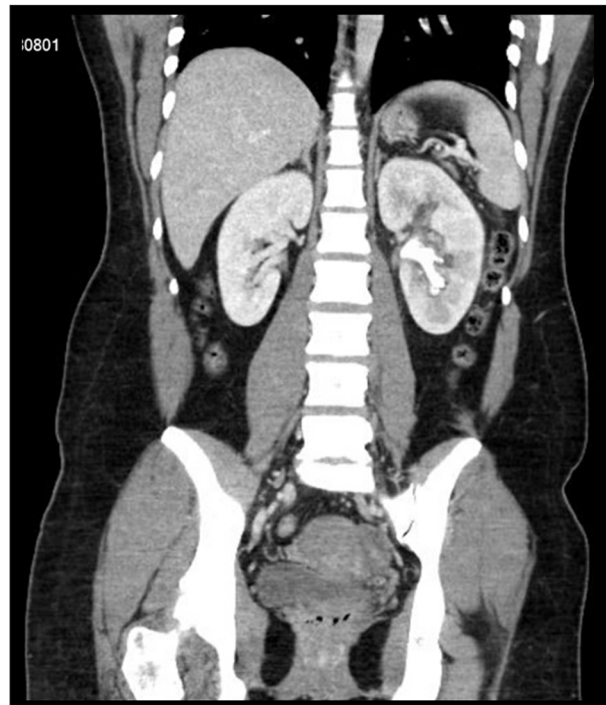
Abdominal computed tomography (CT) imaging in a 28-year-old woman with tubal ligation and obstructive pyelonephritis due to renal calculus with a false-positive urine pregnancy test. Abdomen CT imaging shows a left-sided staghorn calculus resulting in partial ureteric obstruction and hydronephrosis.
